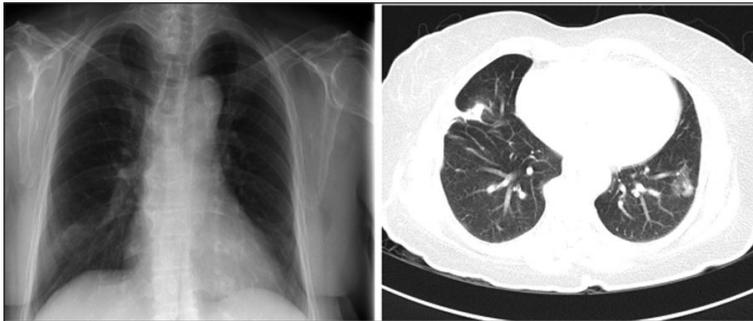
Normal looking chest radiograph cannot totally exclude subtle abnormal changes in the lungs which are better demonstrated on cross sectional imaging CT Scan. Lesions are seen in the right and left lung field on CT Scan
